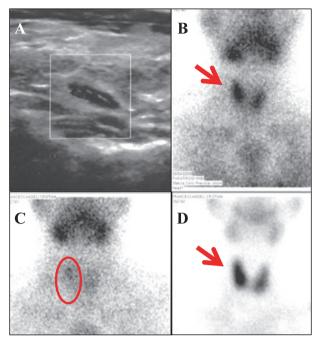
Neck ultrasound (A) and 99mTc-pertechnetate scintigraphy (B-D) reveal an upper right hyperplastic parathyroid gland.
